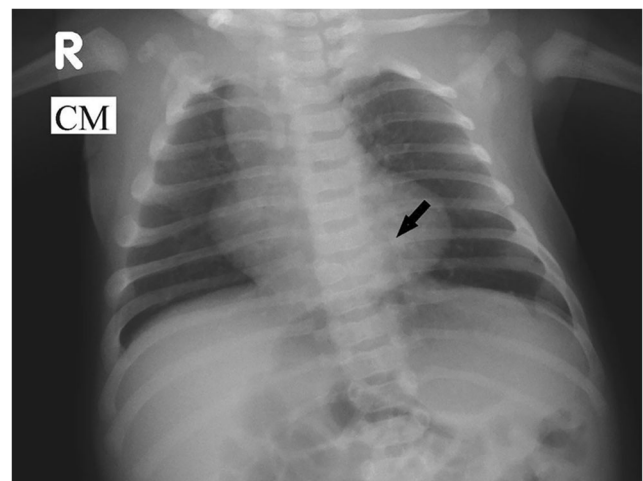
Alagille syndrome in a 2-month-old girl. Anteroposterior radiograph of the chest demonstrates a butterfly vertebra of the mid thoracic spine (arrow)
